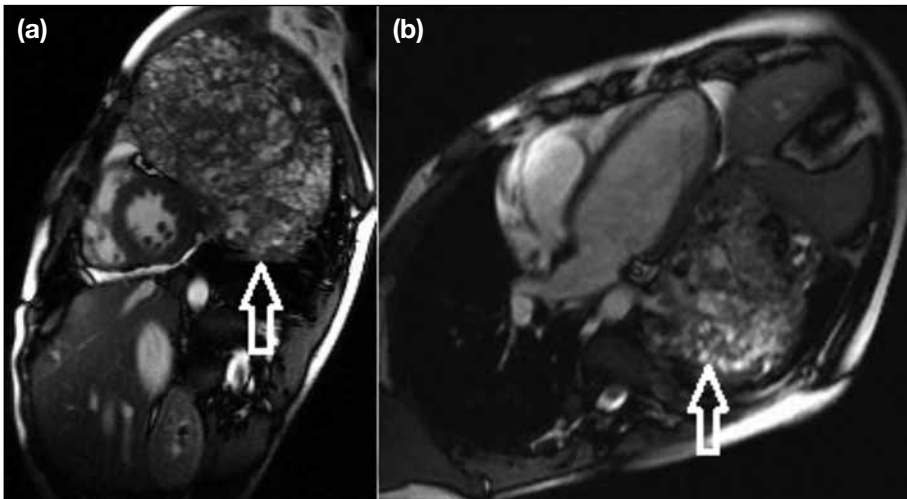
(a, b) Cardiac magnetic resonance images at two sequences of a 14-year-old male patient with a large mediastinal teratoma occupying most of the left hemithorax (arrows). The mass invaded the pericardium of the left ventricle at the level of the midlateral and midanterior myocardial segments with possible invasion of the myocardium. (a) Short-axis cine steady-state free precession gradient echo sequence. (b) Two-chamber cine steady-state free precession gradient echo sequence.
